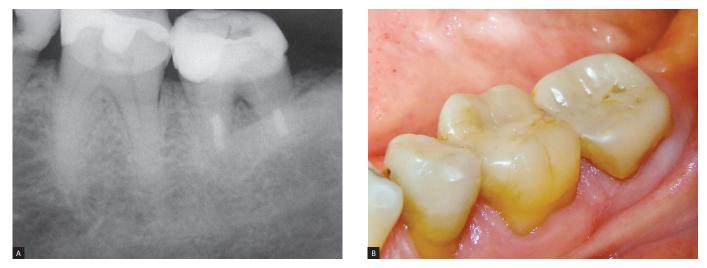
After 10 years, an periapical radiograph (A) reveals no sign of resorption or lesion and clinical examination confirms the success (B).
